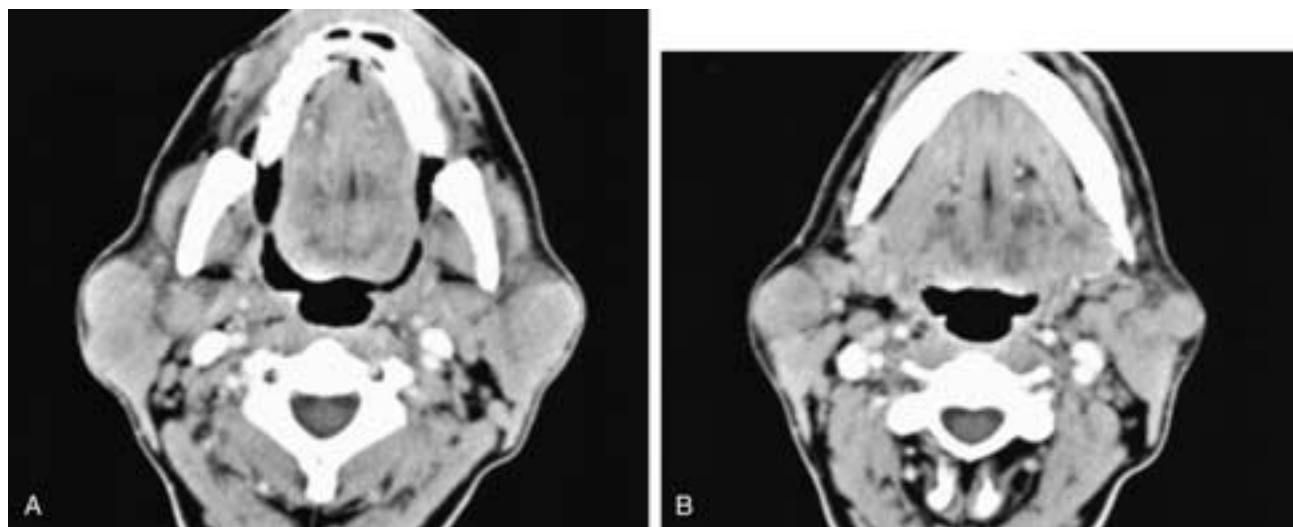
Axial contrast-enhanced CT scans (A, B) show multiple well-defined masses in both parotid glands. There is also lymphadenopathy in the neck bilaterally. This patient had large cell lymphoma.
